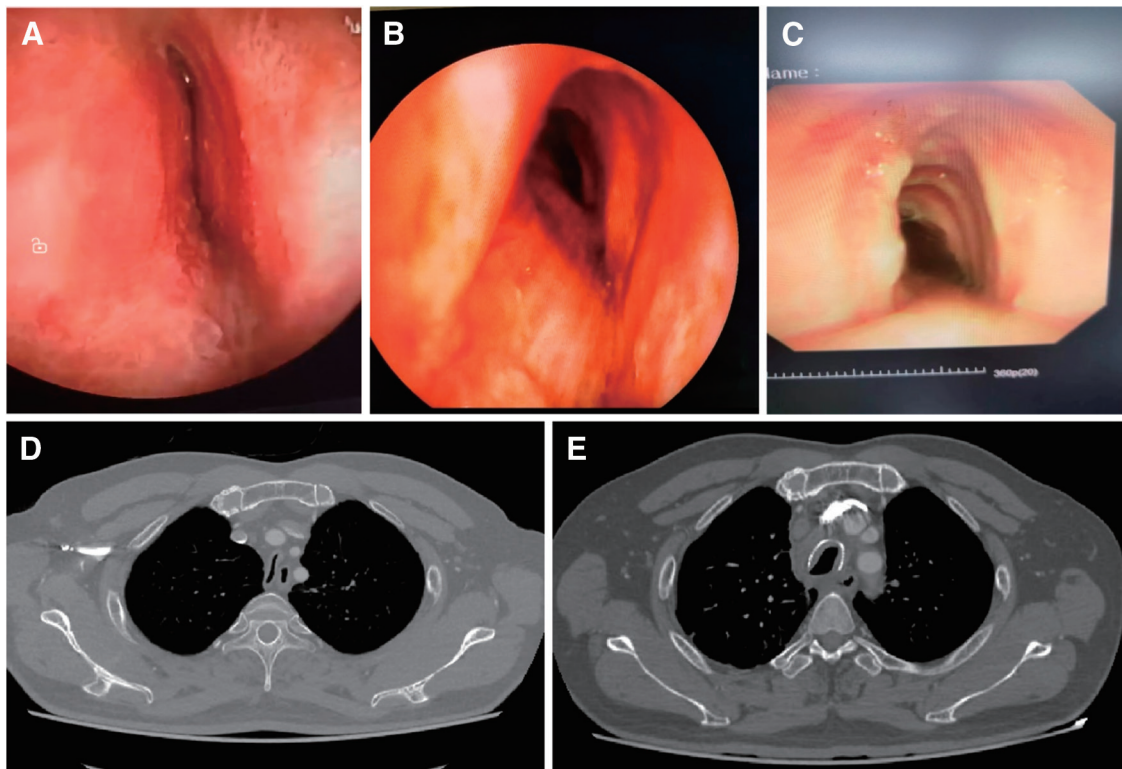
Bronchoscopic and CT images before and after surgery. (A) Preoperative bronchoscopic image of the trachea, (B) intraoperative bronchoscopic image of the trachea, (C) bronchoscopic image 2 weeks after surgery, (D) preoperative chest CT image, and (E) 6 months postoperative chest CT image. CT, computed tomography
